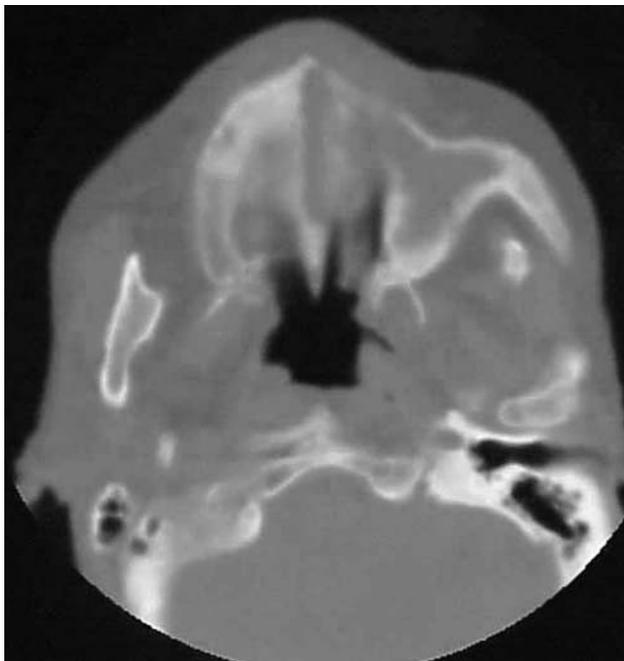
CT scan. The alveolar process and anterior wall of maxillary sinus substituted by low density area, with poor defined margins, limited by hyperostosis of contralateral hemimaxillary medial margin.
